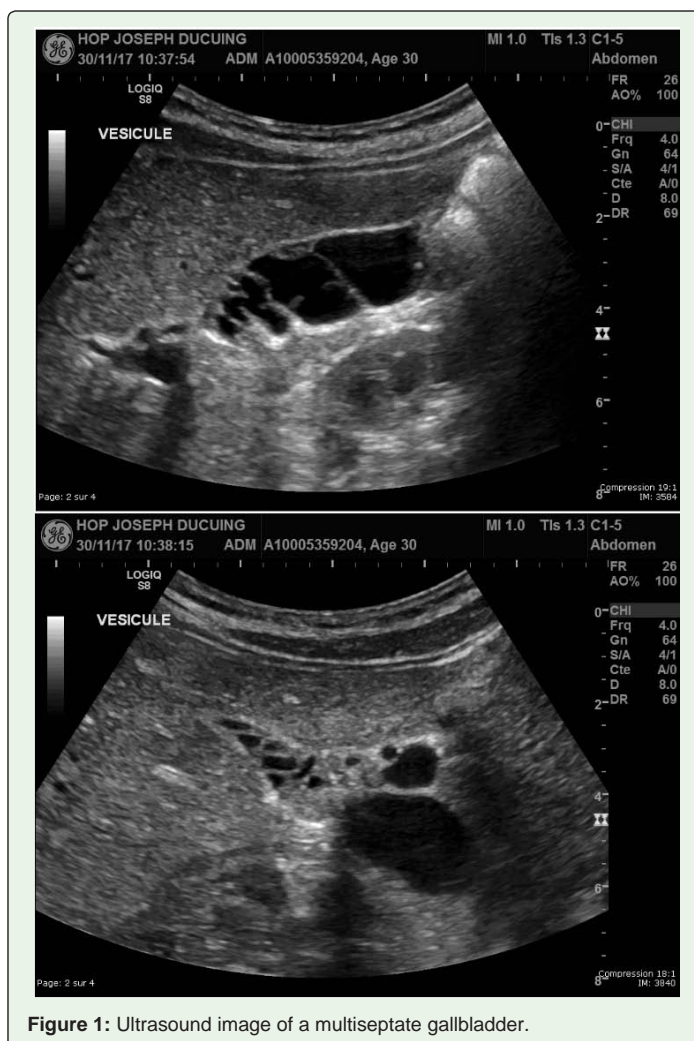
Ultrasound image of a multiseptate gallbladder.
